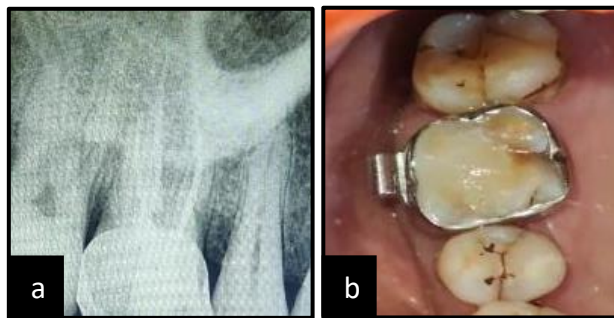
(a and b) Postoperative radiograph and photograph.
